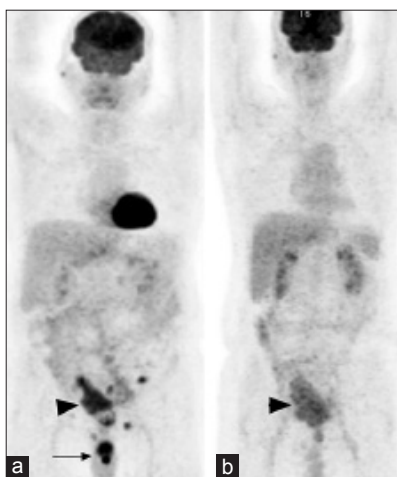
F-18 FDG PET/CT maximum intensity projection image. (a) Intense uptake in the base and shaft of penis (arrow) and physiological uptake in neobladder (arrowhead). Two FDG avid lymph nodes, one left external iliac and one left inguinal, are also visualized. The post-therapy MIP image. (b) Complete resolution of the FDG uptake in the base and shaft of penis as well as in the lymph nodes
